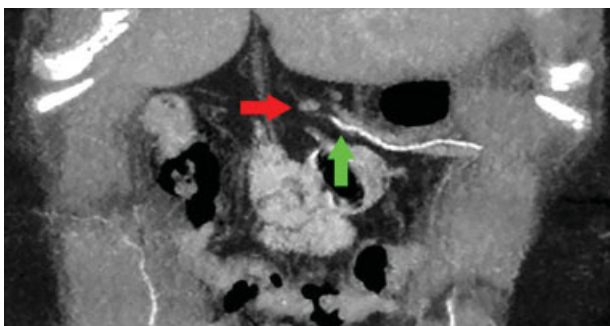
Lymph node located along the right gastroepiploic artery on coronal computed tomography (CT) angiography abdomen imaging. Horizontal arrow is indicative of gastroepiploic lymph node. Vertical arrow is indicative of the right gastroepiploic artery and vein.
